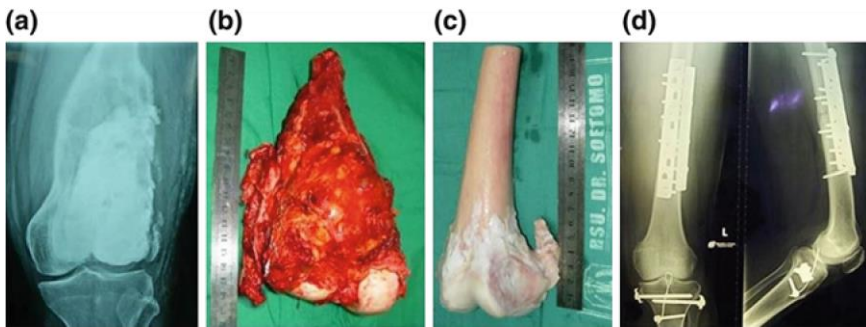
a Giant cell tumor of distal femur, b tumor after resection, c osteoarticular bone allograft (17 cm), d X-ray after reconstruction of the distal femur including knee joint (Courtesy of Dr. Soetomo General Hospital, Surabaya)
